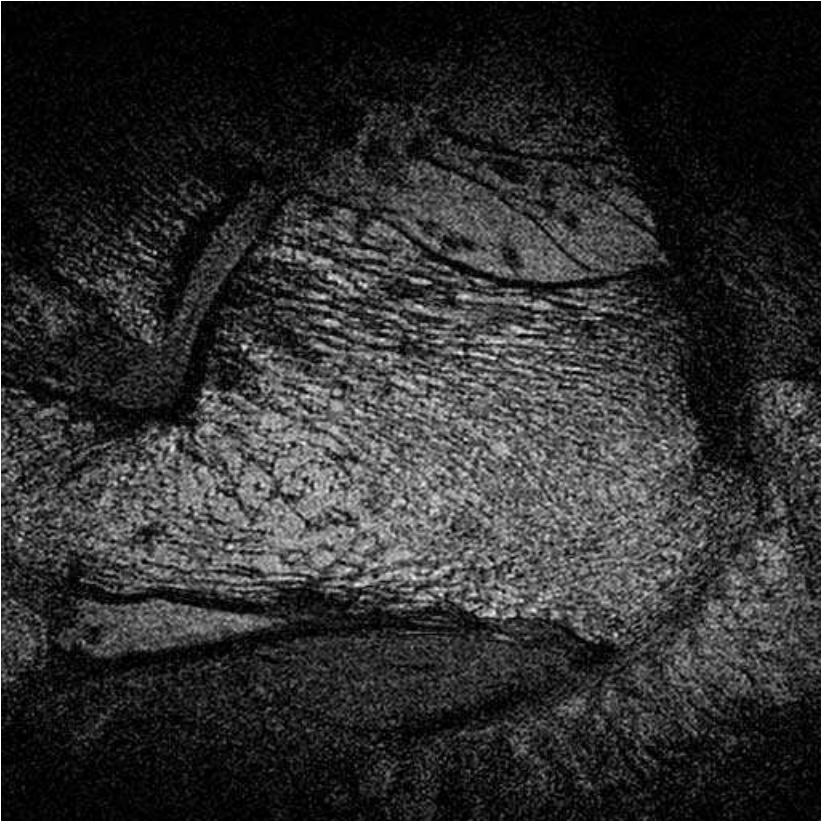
High resolution gradient-echo MR image of the right calcaneus of a young healthy man obtained at 1.5 Tesla using a two-element experimental microcoil (in-plane resolution $156 \times 156 \times 500 \mu\text{m}^3$).
